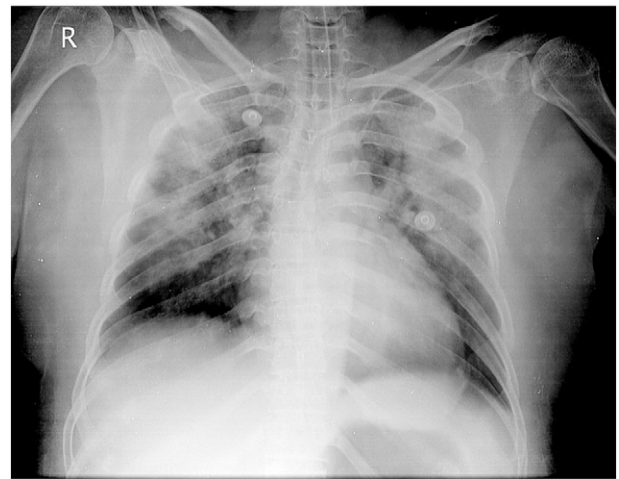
Bedside x-ray chest at ICU admission. X-ray reveals bilateral diffuse infiltrates.
